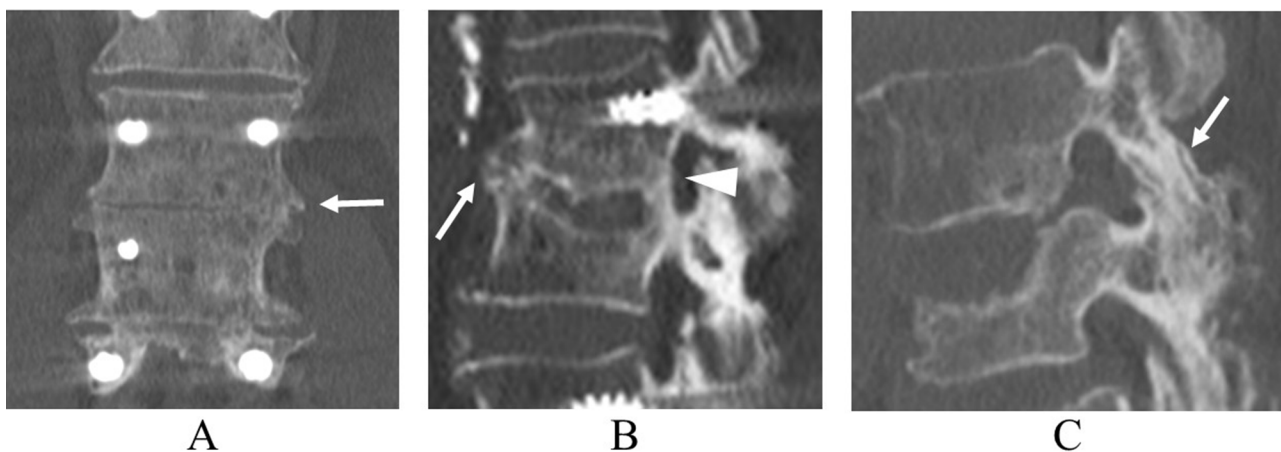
Locations where initial bone union was achieved. Postoperative computed tomography scan evaluated the bone union locations: lateral bridging callus (A arrow), anterior bridging callus (B arrow), posterior bridging callus (B arrowhead), and extra body (spontaneous facet joint union: C arrow)
